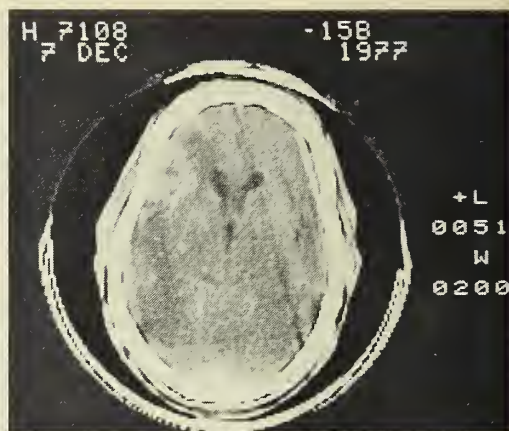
(Left) Post-infusion CT scan showing left frontal mass and no midline shift of the ventricular system. Figure 2 (Right) shows Post-infusion CT scan showing the increased size of the left frontal mass of increased radiodensity surrounded by a zone of decreased density or edema.
